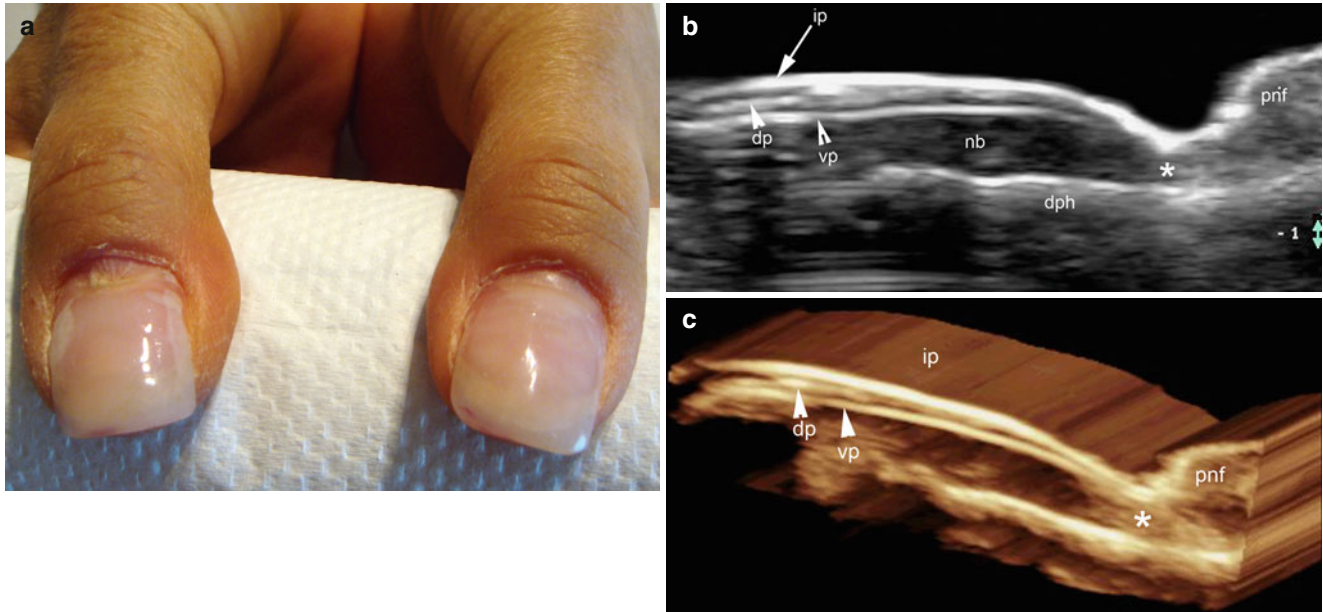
(a–c) Acrylic implant. (a) Clinical image of acrylic implants in the thumbs. (b, c) Sonographic images (longitudinal views; b grey scale and c 3D reconstruction of the right thumb) show a trilaminar hyperechoic structure in the surface of the nail. The upper hyperechoic line corresponds
